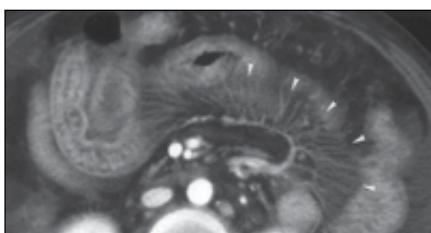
Intussusception: CT scan shows ilio-caecal intussusception (arrow) with central dark mesenteric fat and alternating rings of enhanced mucosa (light ring) and oedematous submucosa (dark ring).
